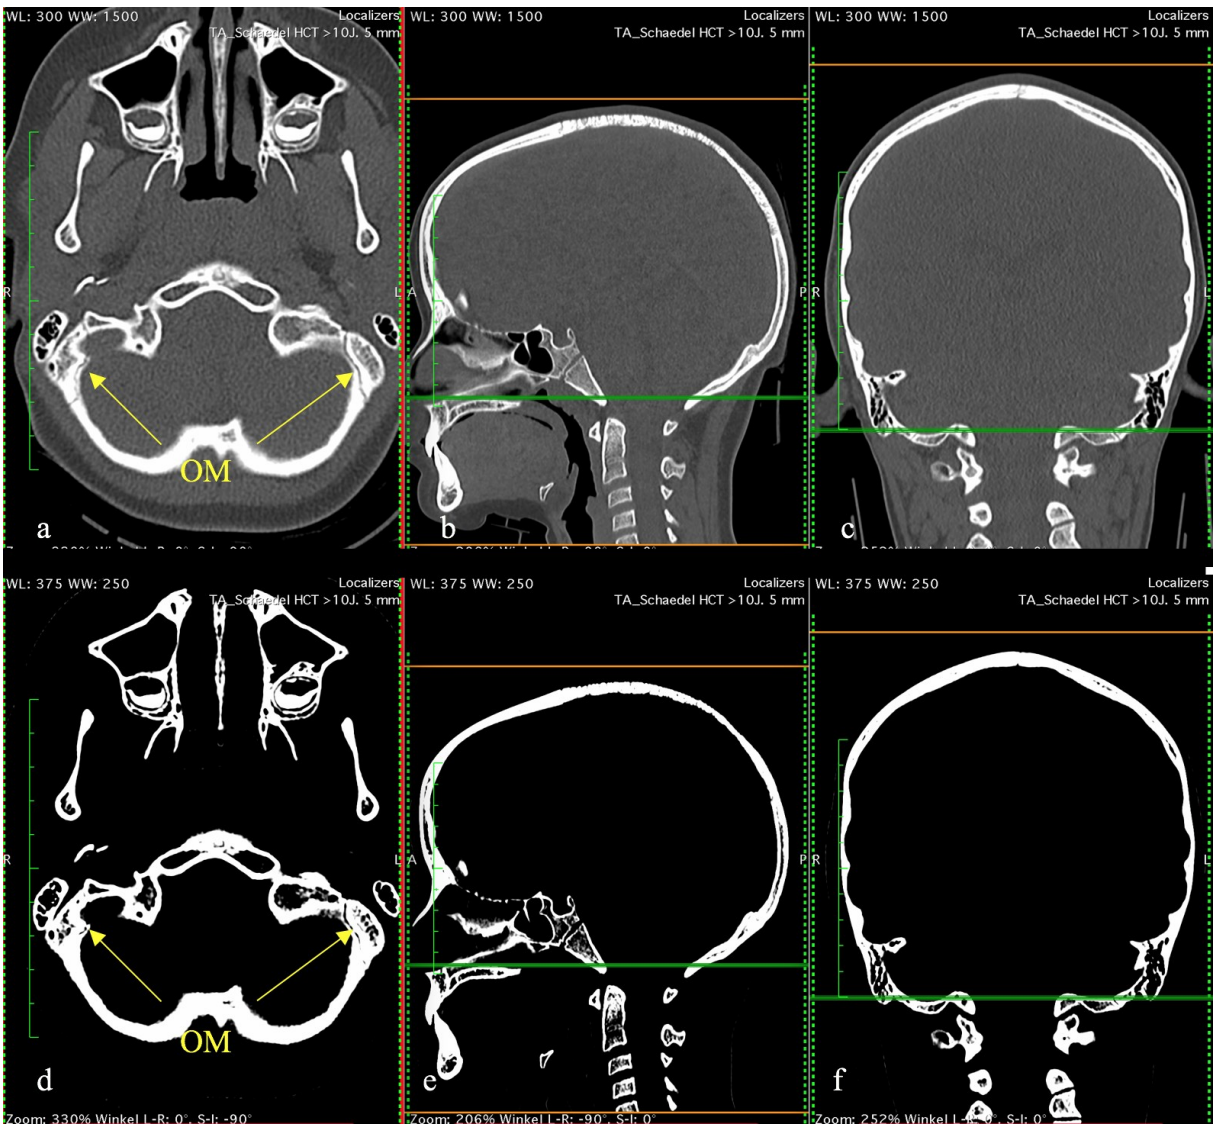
CT image of a skull of a 10 years old female in a-c bone window and d-f manual WW/WL settings in a d axial view, b e sagittal and c f coronal reformat (yellow arrows: left and right occipitomastoid suture).
